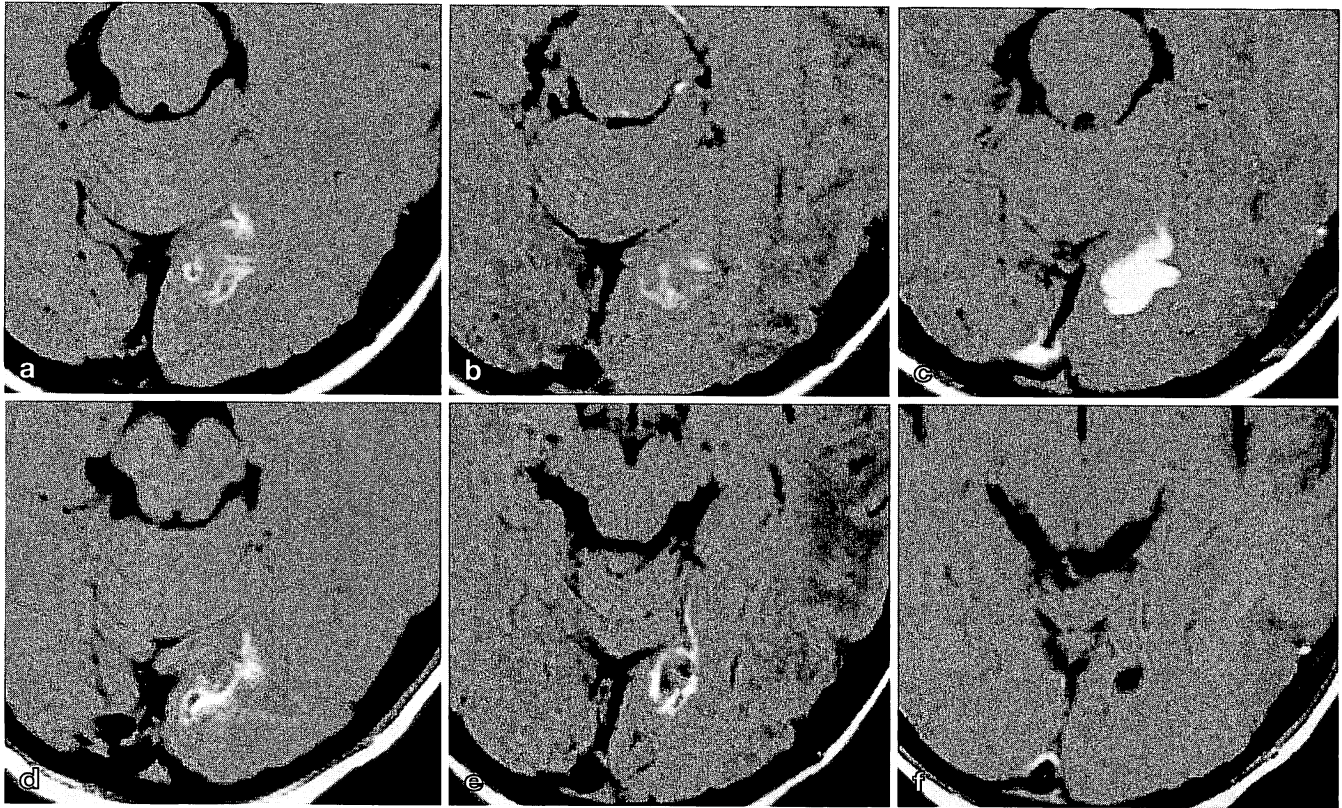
A 23-year-old woman with right occipital infarction. a–c were obtained at 2 weeks after ictus, and d–f at 2.5 months. a T1-weighted spin-echo image shows a high intensity cortical laminar lesion while a subcortical lesion displays iso-intensity. b On the FLAIR image the cortical lesion is iso-intense and the subcortical lesion is slightly high intensity. c Both the cortical and subcortical lesions are markedly enhanced by the contrast material. d The cortical lesion is high intensity while the subcortical lesion is partially low intensity. e The FLAIR image shows the cortical lesion as high intensity and the subcortical lesion as low intensity. f There is no apparent contrast enhancement of the lesions
